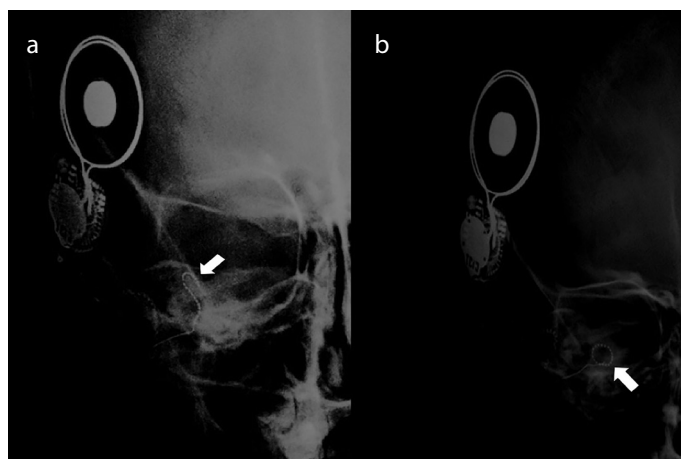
a, b. Anteroposterior X-ray showing electrode (white arrow) in superior semicircular canal before revision (a) and intracochlear electrode after revision (b).
